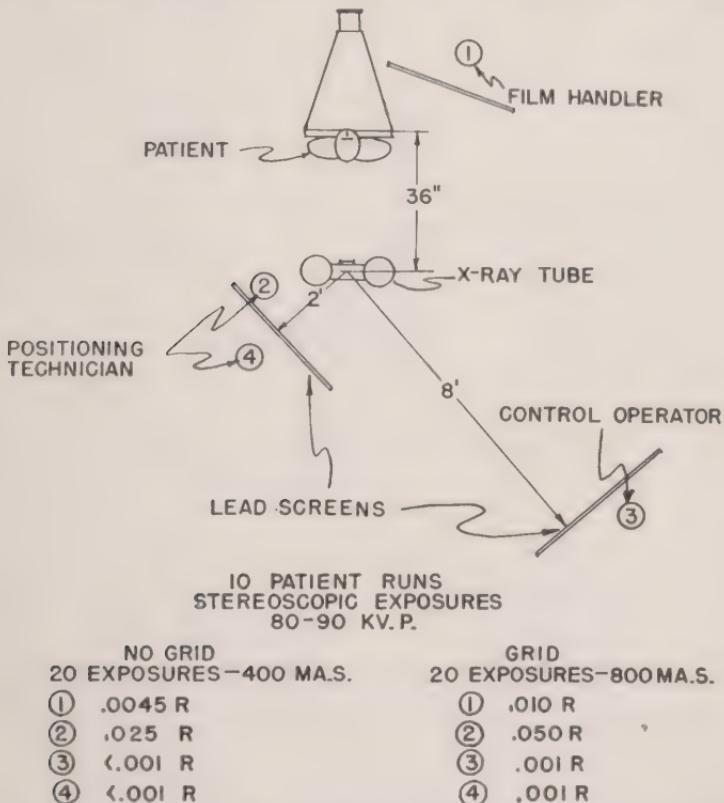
Radiation exposures incurred by technicians. (The values listed represent average values obtained as a result of several testings. The X-radiation exposures will vary, depending upon the arrangement of the mobile lead shields and the positioning of the various items of X-ray equipment.)
